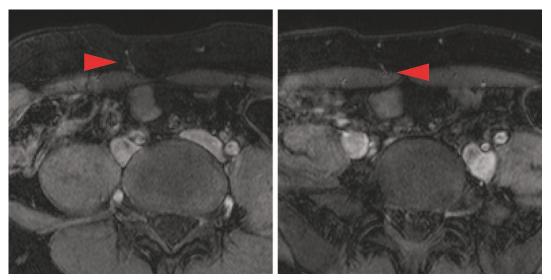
Preoperative magnetic resonance angiography for DIEP flap planning and intraoperative confirmation. 3-T gadolinium-enhanced magnetic resonance imaging scans demonstrate the deep inferior epigastric artery perforator vessels (*red arrows*) as they pass through the anterior rectus sheath and enter the subcutaneous fat of the anterior abdominal wall. Preoperative mapping identified these two perforators as the dominant vessels with the largest diameter of all vessels seen with a course into the infraumbilical subcutaneous tissue. Preoperative mapping of these vessels in relation to the umbilicus suggested that these perforators originated from the medial row branch of the deep inferior epigastric vessels and were aligned along a craniocaudal plane. The craniocaudal alignment of the visualized perforating vessels was confirmed at surgery. This anatomy permitted the harvest of both sets of perforators in continuity without transection of the rectus abdominis muscle. Intraoperative time was minimal, as the need to isolate all surrounding perforators was eliminated.
